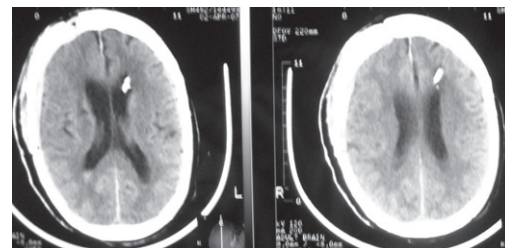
Follow-up CT showing resolution of ventricular size following an indwelling ventriculoperitoneal shunt.
